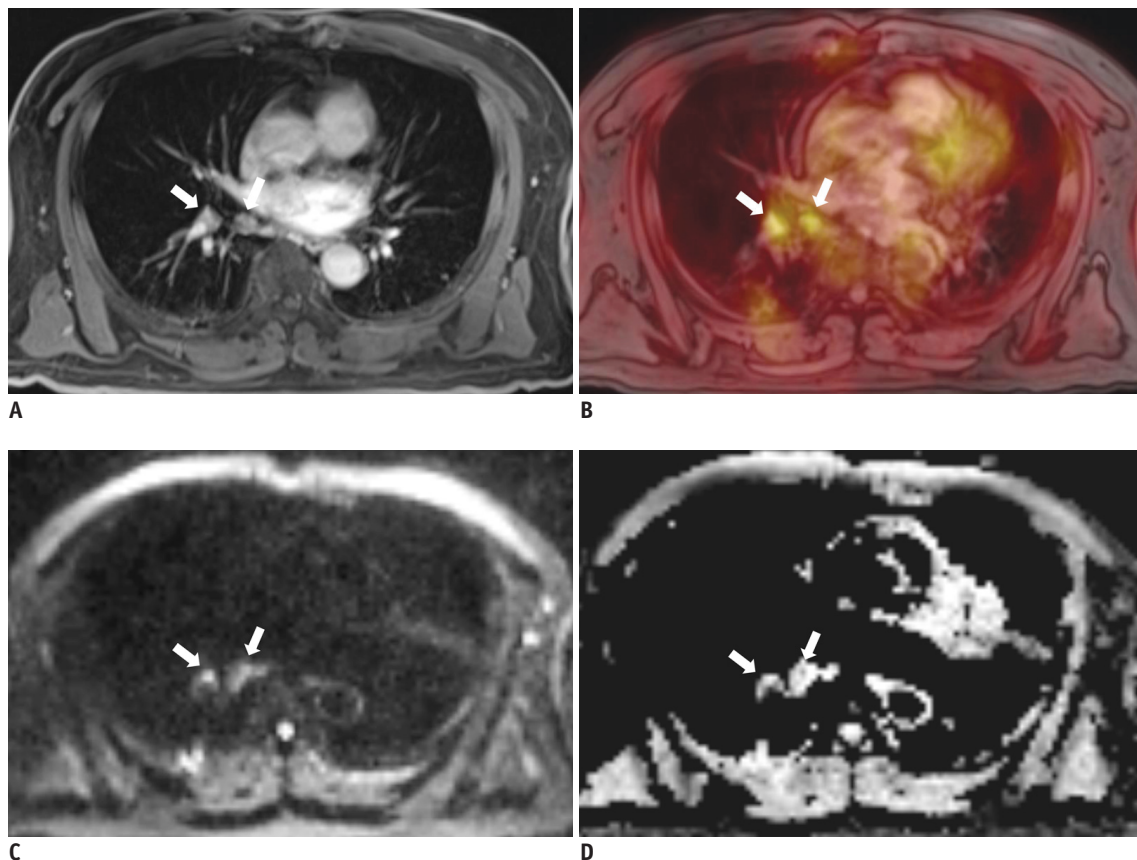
66-year-old man with 3.7-cm lung mass (not shown) in right lower lobe. A. Axial, post-contrast, three-dimensional volumetric interpolated breath-hold examination image showed two small right interlobar lymph nodes (arrows). B. Axial fused FDG-MR/PET image showed increased FDG uptake in interlobar nodes (SUVmax: 4.4 and 3.8). Axial, DWI (b = 400) (C) and ADC map showed diffusion restriction in two lymph nodes (D). Concordant findings of right interlobar lymph nodes on ADC map and on fused MR/PET image increased our confidence in reporting right interlobar lymph-node metastasis, and pathology results confirmed right interlobar lymph-node metastasis. ADC = apparent diffusion coefficient, DWI = diffusion-weighted image, FDG = fluorodeoxyglucose, MR/PET = magnetic resonance imaging/positron emission tomography, SUVmax = maximum standardized uptake value
